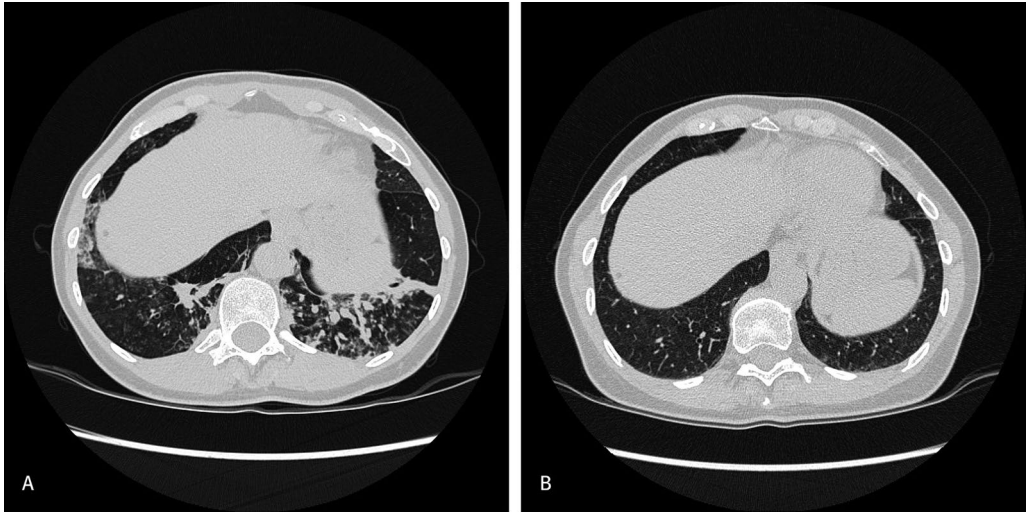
(HR)CT shows improvement of the radiological features of bronchiectasis; mucus plugging, parenchymal disease and peribronchial thickening.
